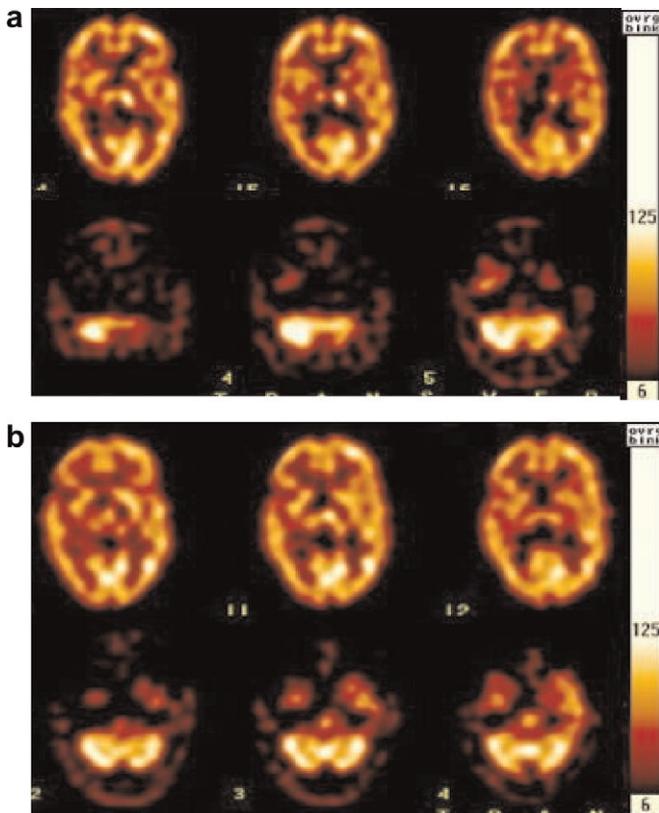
SPECT brain perfusion images obtained before rehabilitation treatment (a) and after 14 days of rehabilitation (b). Note the relatively increased tracer uptake in the left thalamus before treatment and decreased blood perfusion in the left cerebellar hemisphere in the left cerebellum after 14 days of rehabilitation.
